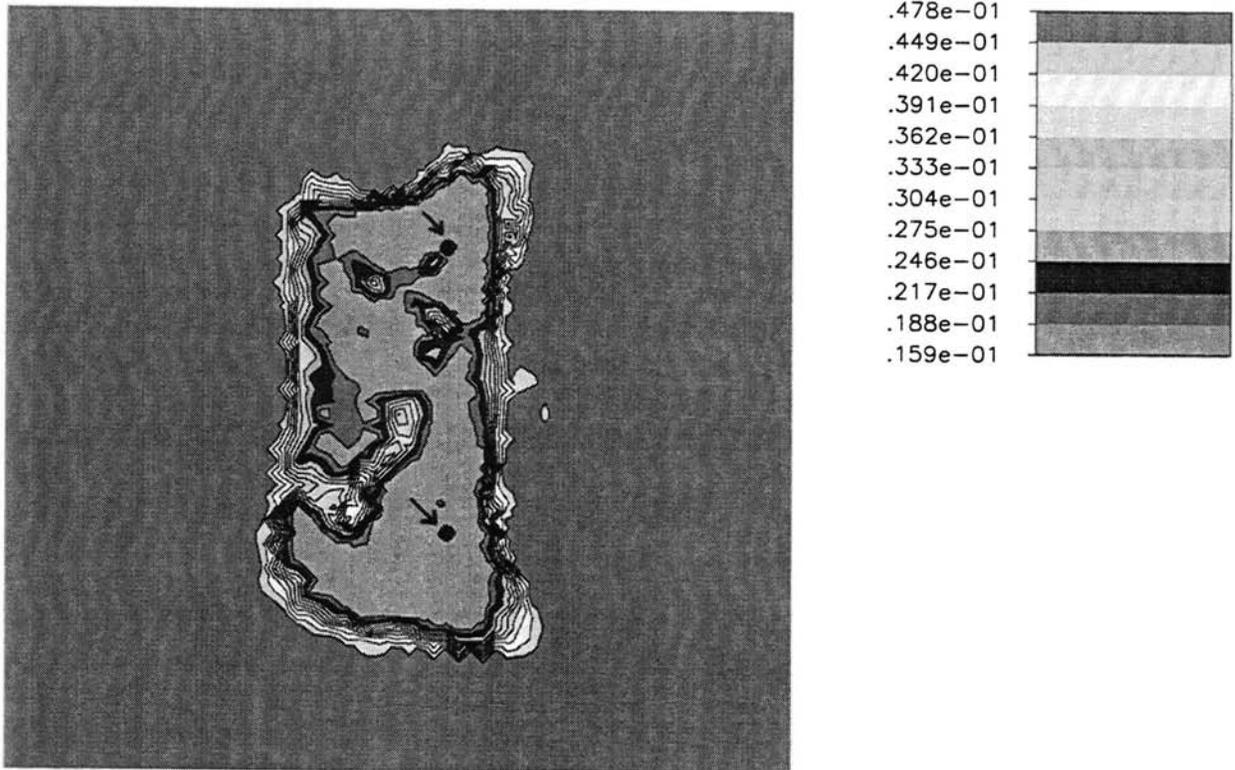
MRI cross-section with "tumors"
